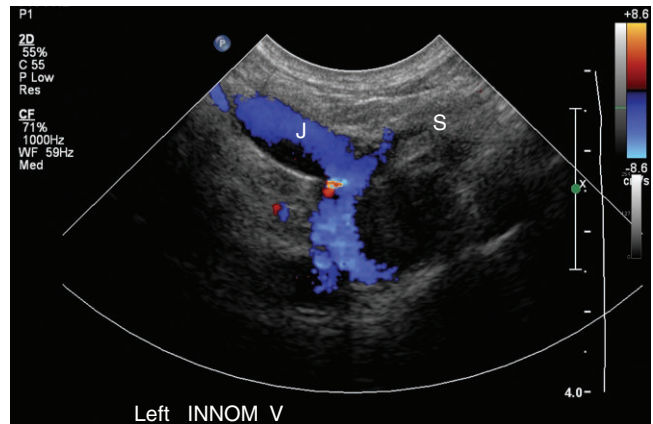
Color Doppler obtained in the same plane as [Figure S74-3](#). The thrombus appears as a color filling defect in the innominate vein. The subclavian vein (S) is obstructed and the jugular vein (J) is patent. Note the echogenicity of the thrombus is less when the color Doppler is active.
